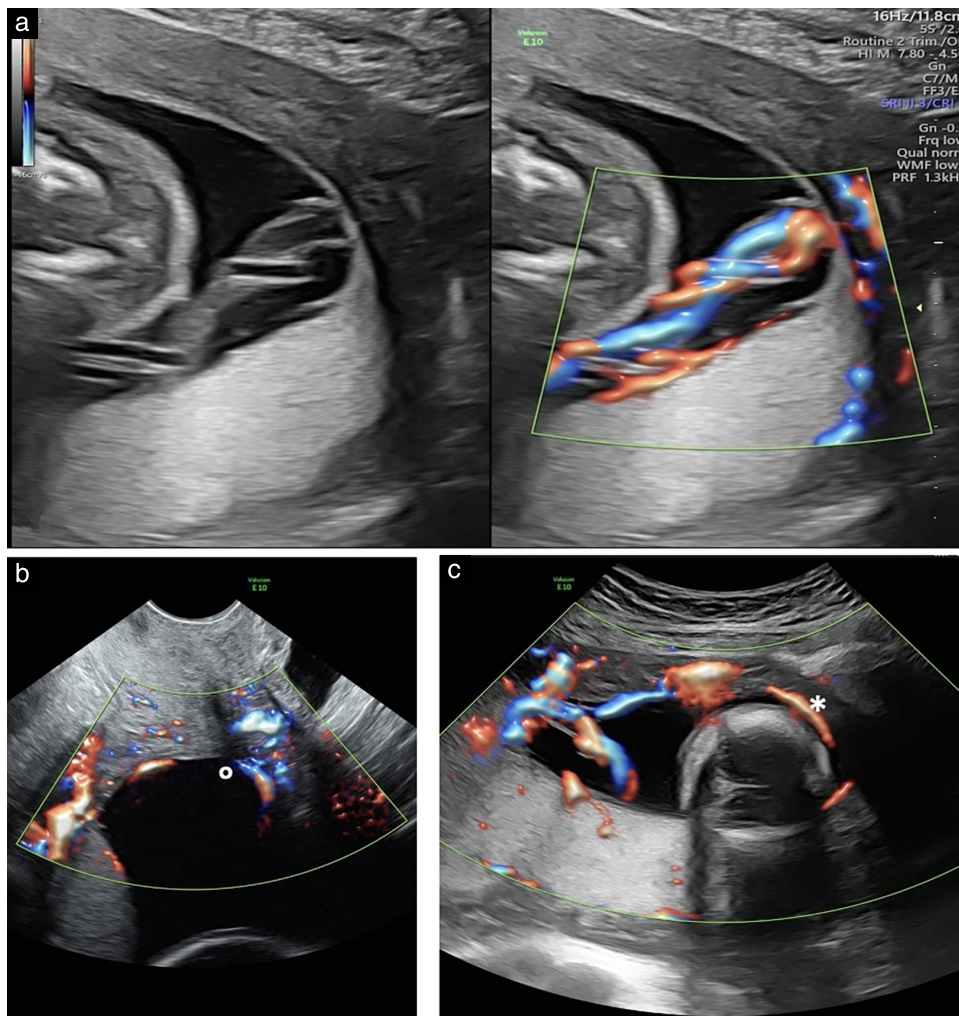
Ultrasound images at 21 weeks' gestation in pregnancy with Type-III vasa previa from our personal experience (Case 2). (a) Transabdominal image in longitudinal view with and without color Doppler, showing marginal cord insertion. (b) Transvaginal color Doppler image in longitudinal view, showing fetal vessels emerging from cord and running along amniotic membranes over internal cervical os (O). (c) Transabdominal color Doppler image in longitudinal view, showing aberrant vessel distal to marginal insertion, with a 'boomerang orbit', emerging from cord, running along amniotic membranes over the cervix as a free loop (*) and returning subsequently to placenta.
